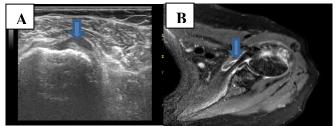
Male patient 44years complaining of partial subscapularis tendon tear; US (A) show hypoechoic defect at its insertion to lesser tuberosity with loss of its fibers continuity; MRI (B) show hyper intense signal intensity at insertion of subscapularis tendon. Case V
